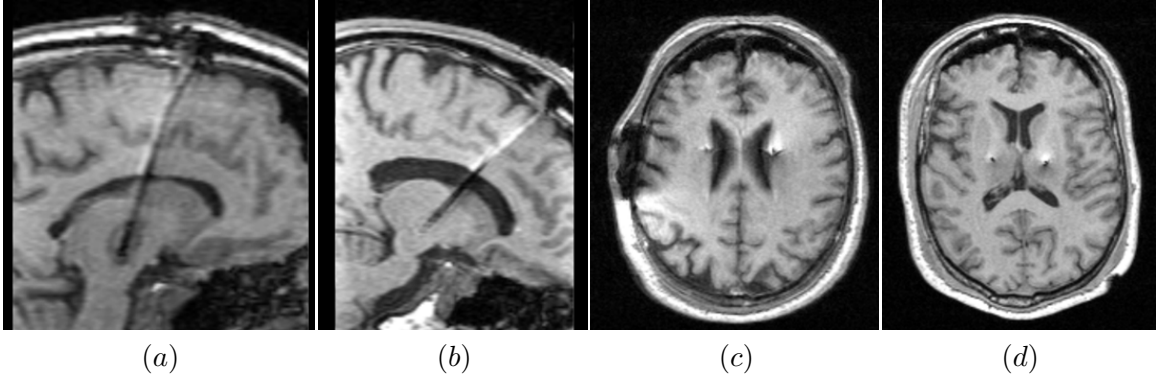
Examples of post-op MRI of subjects with transventricular DBS lead implantation (a and b) and bilateral pneumocephalus (c and d). Their mean/max shifts were (a) 2.7/3.9 mm , (b) 2.0/2.8 mm, (c) 2.1/2.9 mm, and (d) 1.5/1.9 mm.
